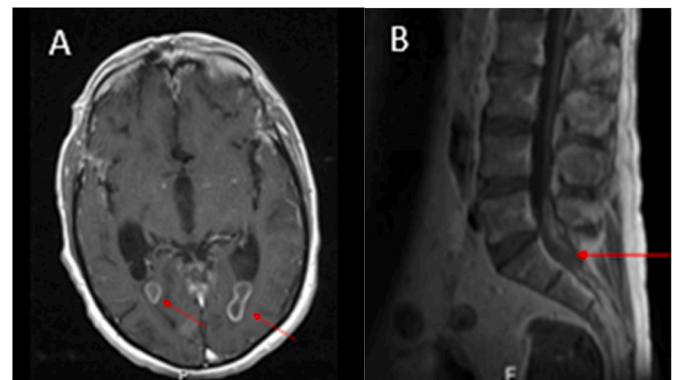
Cranioencephalic (CE) and neuroaxis magnetic resonance imaging (MRI) performed on day +16. A- Focal lesions on occipital horns of both lateral and fourth ventricles in T1-weighted image (lesions are pointed with red arrows); B- Grossly fusiform expansive lesion with a probable intradural location (at L5-S1 level) with T1-weighted image (lesions are pointed with red arrows). (For interpretation of the references to colour in this figure legend, the reader is referred to the Web version of this article.)
